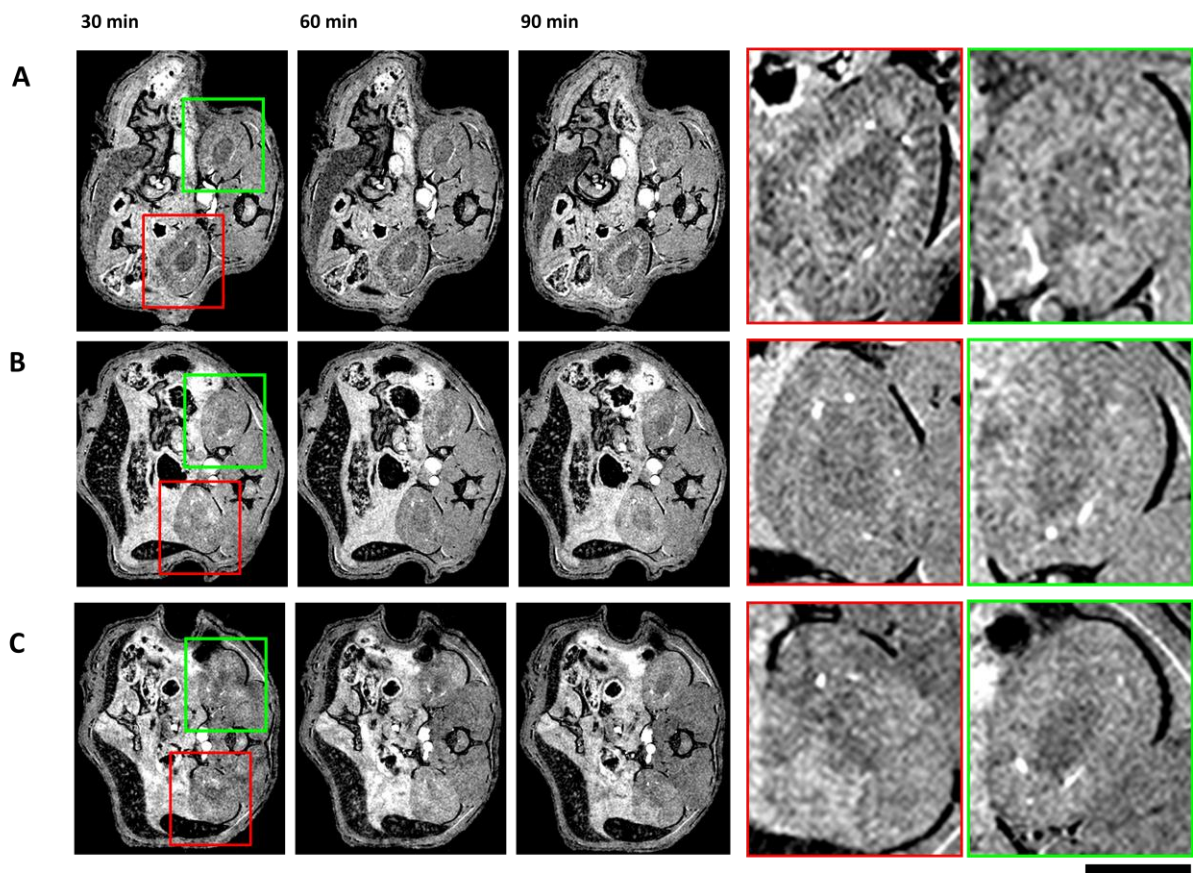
Serial *in-vivo* MRI detected VCAM-MPIO in kidneys.
